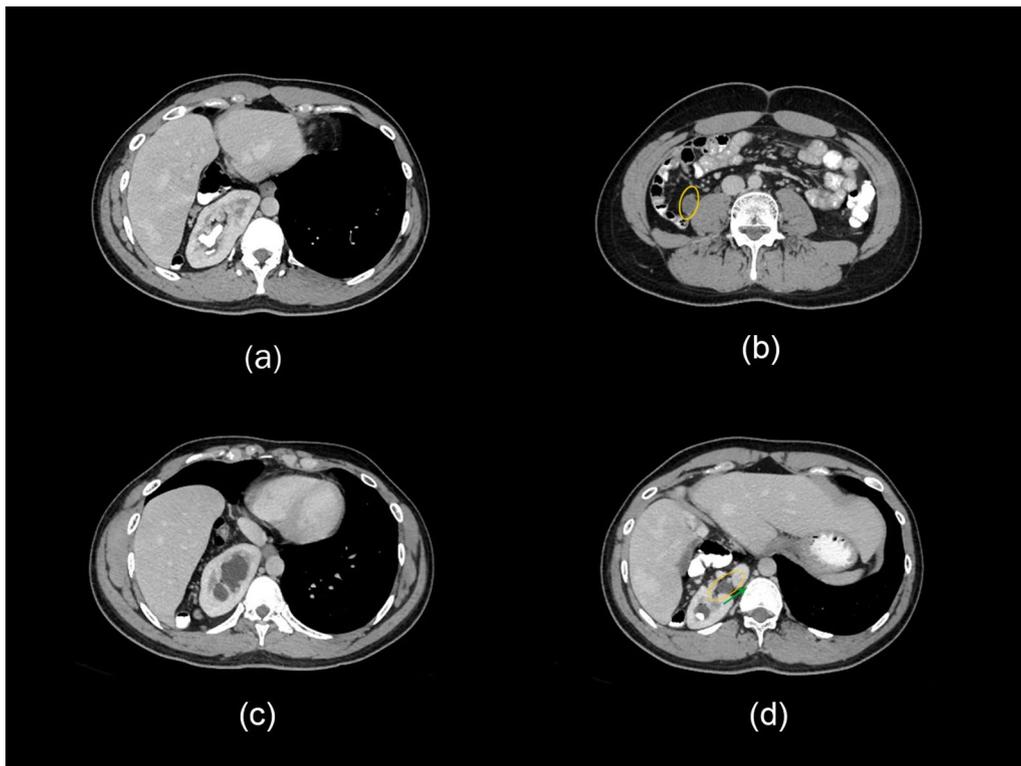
a CT showing superiorly displaced right kidney, liver and bowel loops. b CT showing right testis (encircled in yellow) lateral to and abutting right psoas muscle at L4 level. c CT showing right thoracic kidney upper pole calyces dilatation. d CT showing malrotated right thoracic kidney with the renal hilum facing anteromedially (hilum structures are encircled in yellow and the direction is shown by a green arrow)
